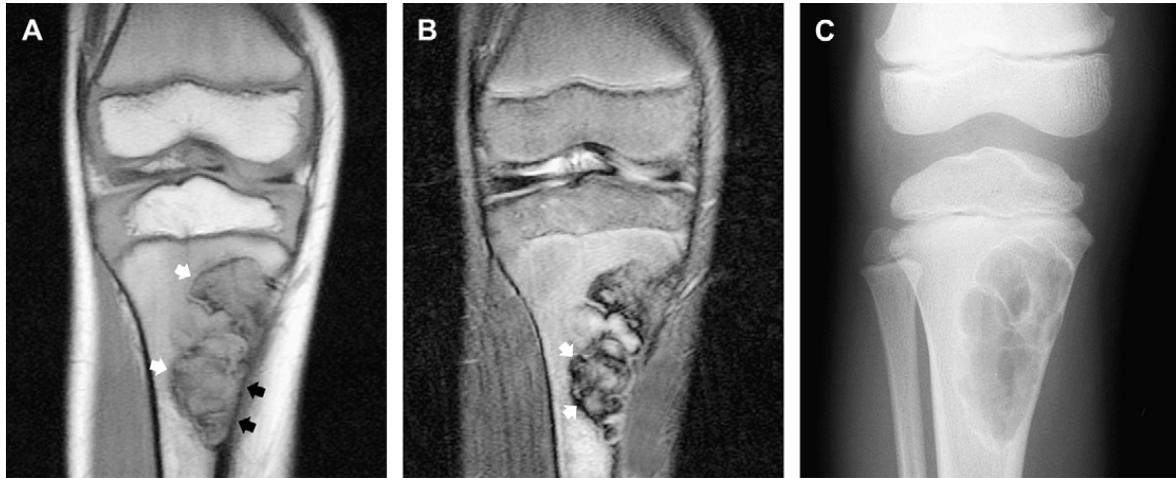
Fibroxanthoma (nonossifying fibroma) in the proximal tibia of an 8-year-old boy. (A) Coronal T1-weighted (TR/TE; 500/14) spin-echo MR image shows a lobulated lesion (*white arrows*) in the metadiaphysis, with mild cortical scalloping and remodeling (*black arrows*). (B) Corresponding coronal fat-suppressed turbo T2-weighted (TR/TE; 4500/88) spin-echo MR image shows the lesion to have a low signal intensity. Note areas of markedly decreased signal intensity with “blooming,” compatible with areas of hemosiderin deposition (*arrows*). (C) Anteroposterior radiograph of the knee shows a lobulated geographic lytic lesion with a sclerotic margin, eccentrically located in the metadiaphysis with mild cortical scalloping and remodeling, typical of a fibroxanthoma.
